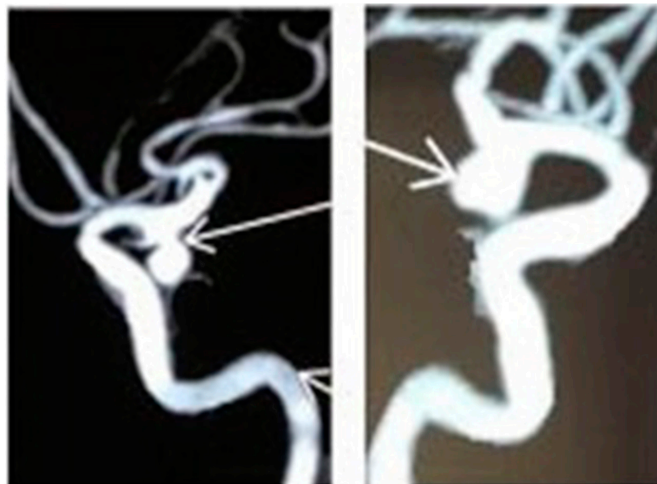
CT angiogram showing a bilateral PCCOM aneurysm. Source: Figure by authors.
